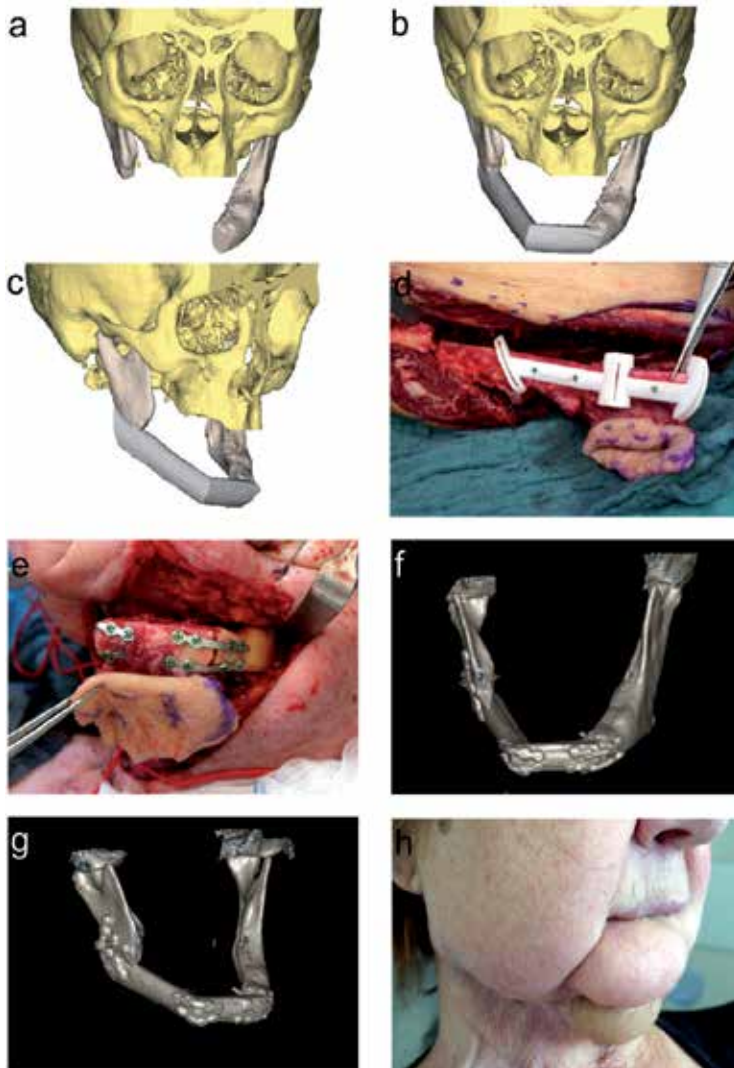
Case 3. (a) Initial mandibular defect in the 3-D CT. (b) and (c) Virtual reconstruction with a two-segment fibula flap. (d) Intraoperative positioning of the fibular cutting guide. (e) Inset of the prepared and osseous segmented osteomyocutaneous fibula flap. (f) and (g) Postoperative 3-D CT of reconstructed mandible. (h) Complete wound healing after 4 weeks.
